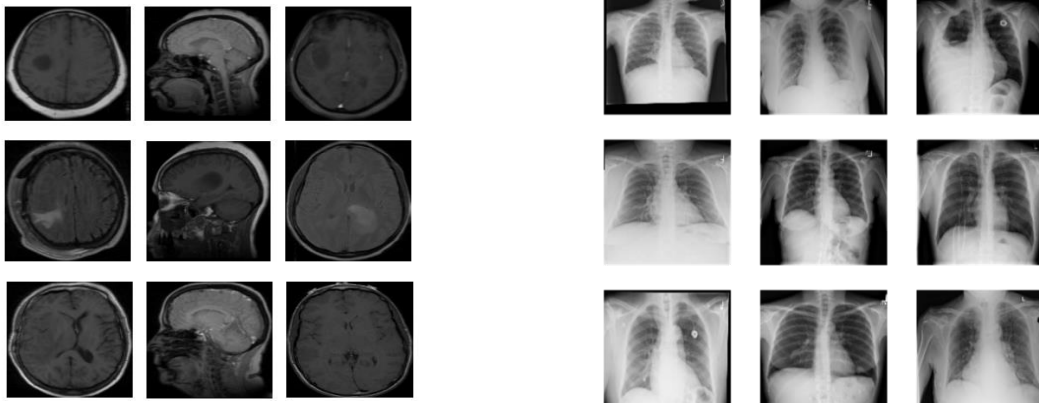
Sample images from REMBRANDT (left) and NIH X-Ray (right) datasets
